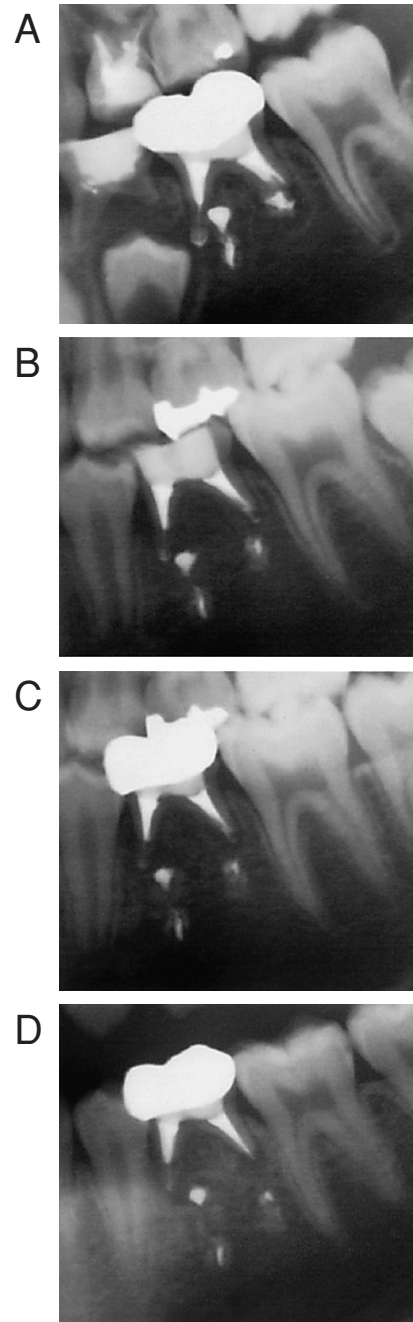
Magnification of the mandibular primary molar area of the orthopantomographs images taken at 7Y6M (A), 10Y3M (B), 11Y1M (C) and 14Y4M (D) in Case 1
